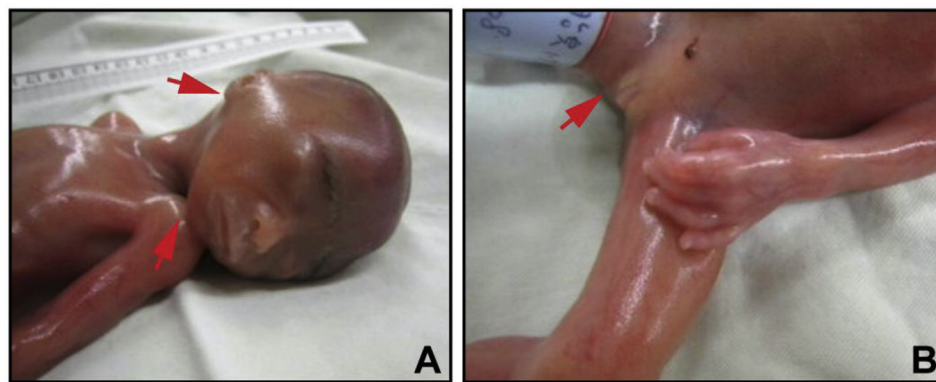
The arrow denotes the site of abortus showing bilateral low-set ears and micrognathia (A), and female sex and clitoromegaly (B), similar to the previous ultrasound images.
